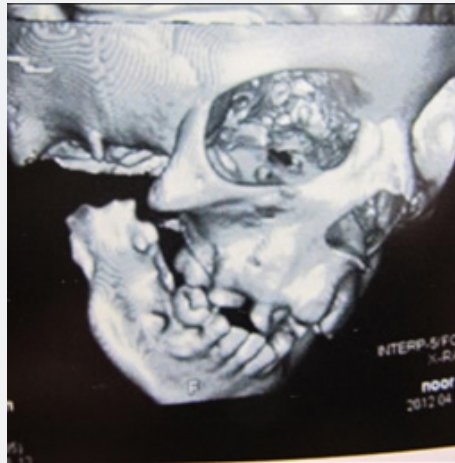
Three-dimension CT scan showing missing glenoid fossa, zygomatic root of temporal bone, TMJ and upper part of ascending ramus.
